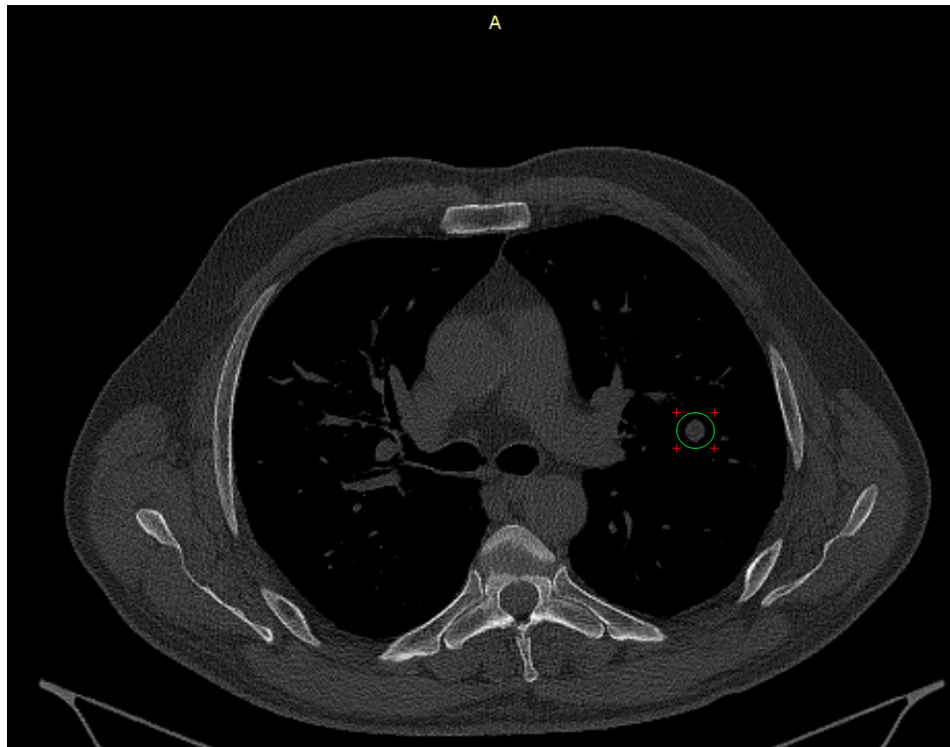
and Figure 3. Chest CT scans indicating the solitary nodule
